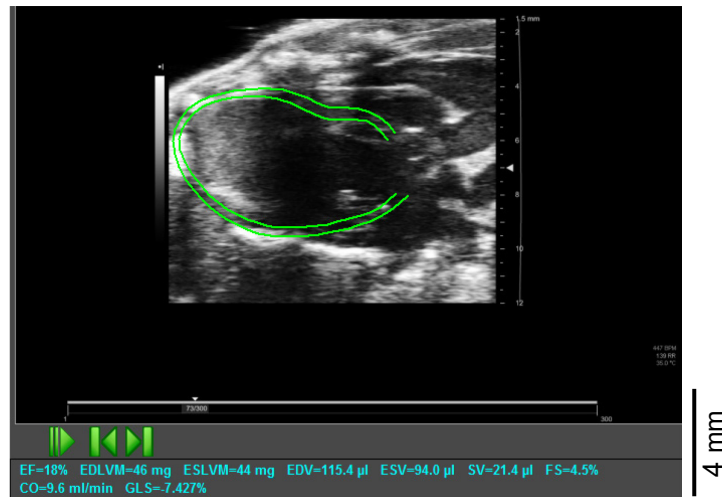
Analysis of cardiac contractility by Vevo Strain Software. Representative strain analysis of an infarcted heart in B-mode parasternal long axis view by Vevo® Strain technology. Left ventricular tracing (green) outlines endocardial border (inner) and epicardial border (outer) over two cardiac cycles for advanced assessment of traditional LV functional parameters and global deformation by strain (cyan).
